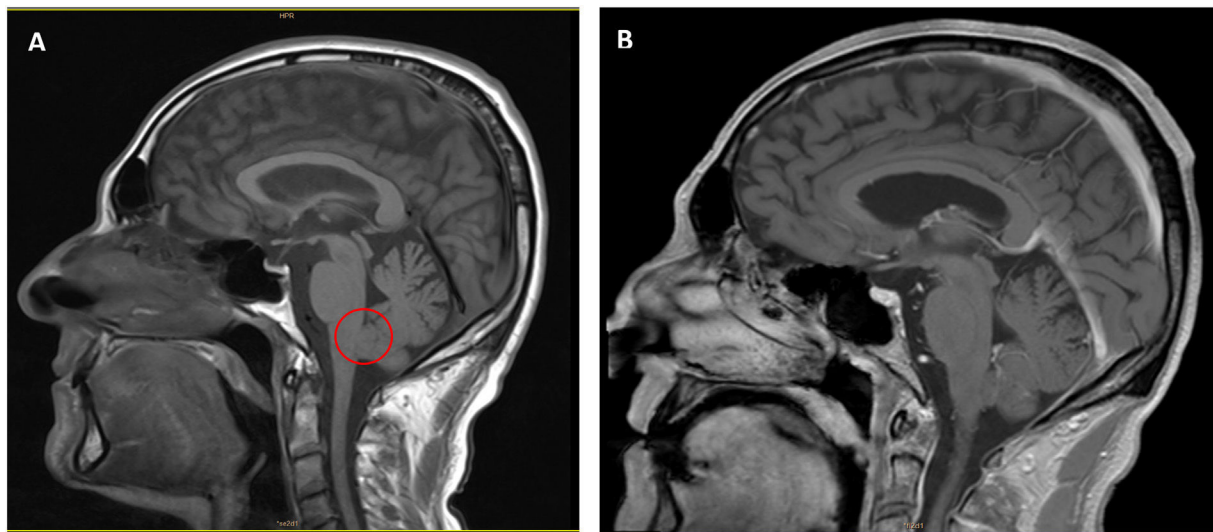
Sagittal slices from T2-weighted (A) and T1-weighted (B) contrast MRI studies, showing a lesion measuring 14 mm craniocaudally, 13 mm transversally, and 9 mm anteroposteriorly, of extra-axial appearance and located at the obex of the fourth ventricle. No oedema or perilesional gliosis is observed. The signal is relatively homogeneous, with no diffusion restriction and no enhancement after intravenous contrast administration; this is compatible with subependymoma of the fourth ventricle.
